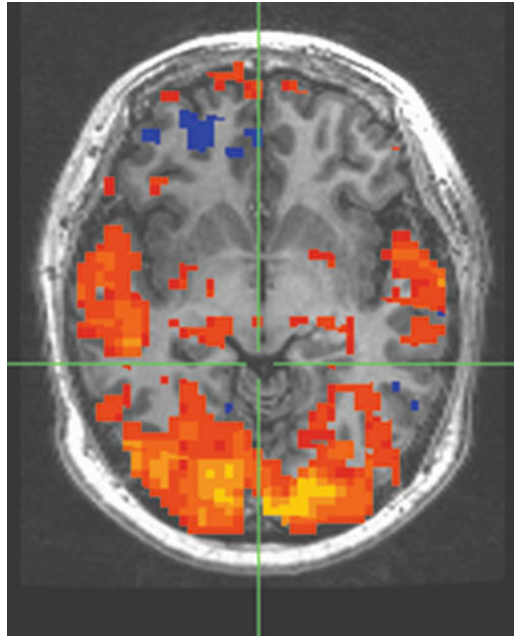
Example of an anatomical and structural MRI of a child
